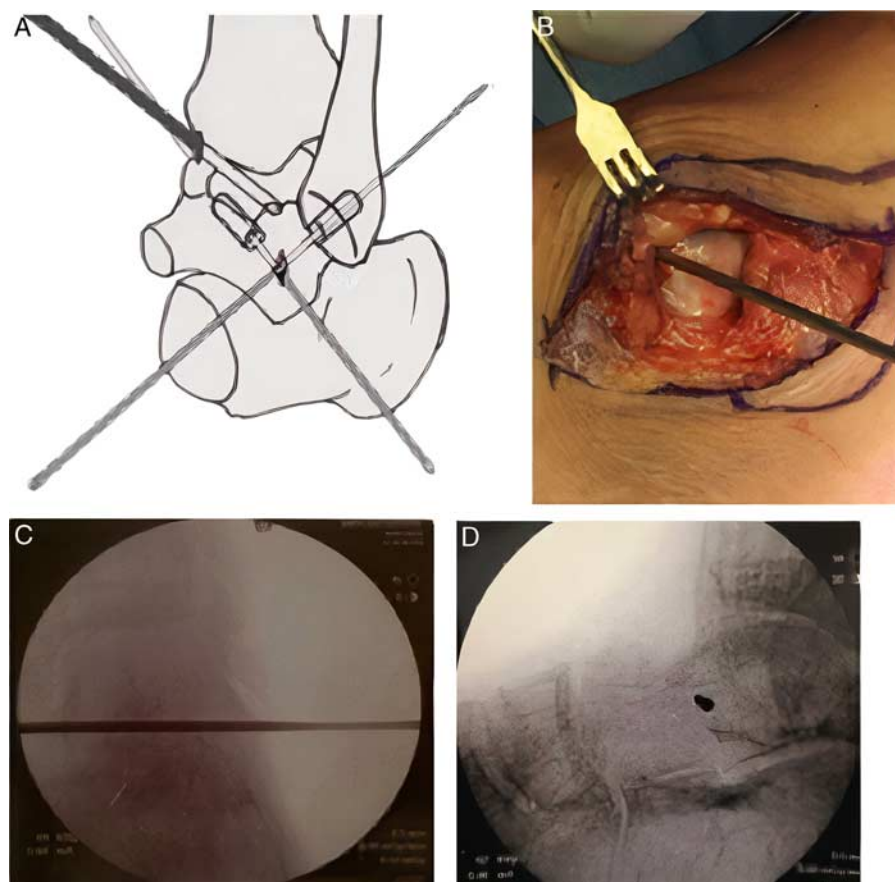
Construction of the talar bone tunnel to serve as the docking site for the talar stem of the anatomic Y-graft. A, The location of the guide pin in the talus directed slightly proximal and posterior toward a point just distal and anterior to the tip of the medial malleolus. B, Intraoperative photo showing the entry site of the guide pin. C and D, Anteroposterior and lateral radiographs to confirm central location of the guide pin to avoid iatrogenic talus fracture with eccentric pin location during the reaming step.
